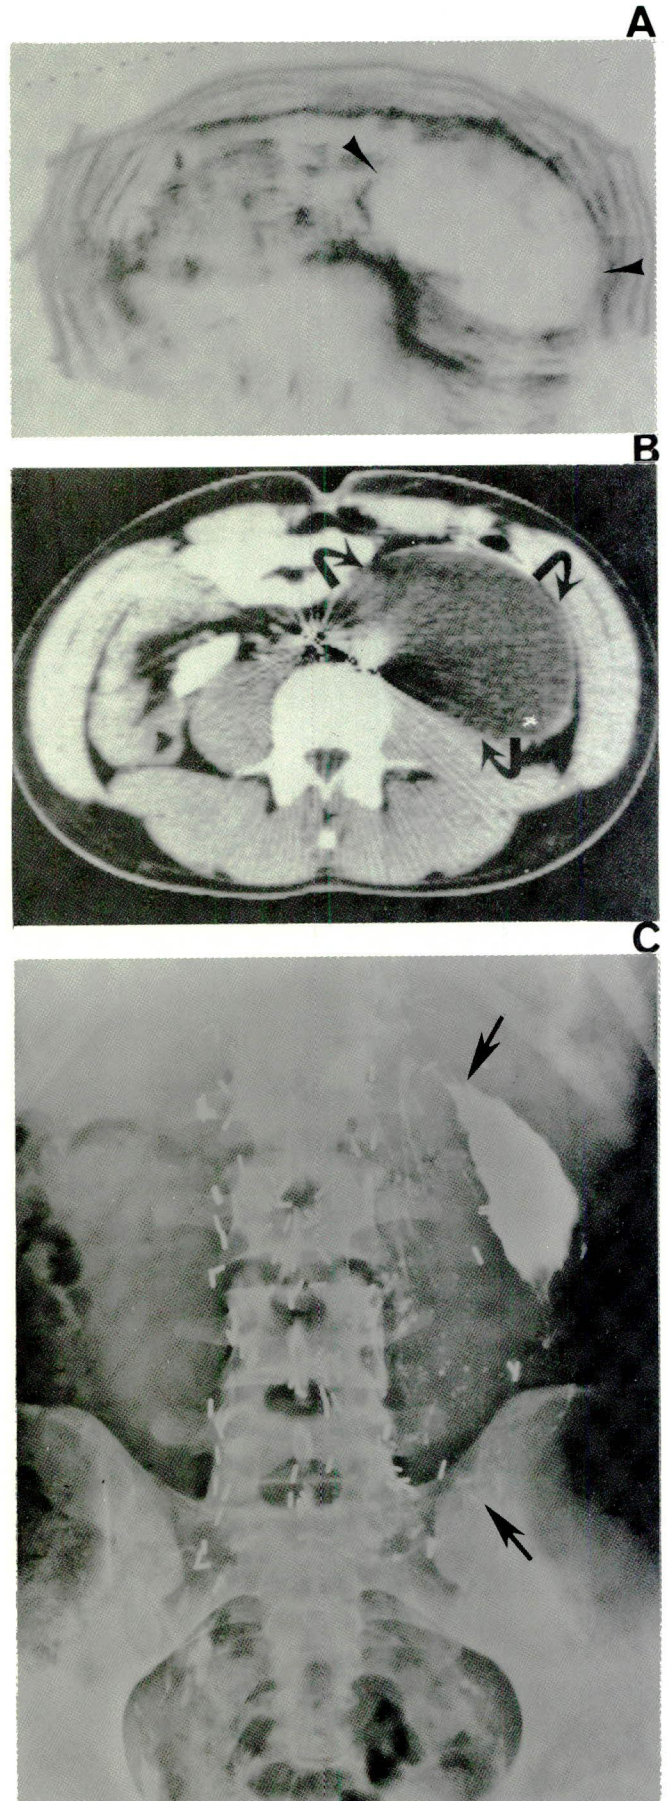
Postoperative lymphocele. 20-year-old male with history of the right testicular mixed germ cell tumor and retroperitoneal lymph node dissection three months previously. A. Transverse sonogram showing large fluid collection in the left side of abdomen (arrowheads). One thousand ml of clear yellowish fluid containing lymphocytes aspirated. B. CT scan 3 days later showed reaccumulation of the fluid (curved arrows). Urogram (not shown) revealed displacement and obstruction of the left ureter. C. Abdominal film following drainage of 1200ml of fluid and injection of pantopaque and ethanol. Notice the contrast material outlining the large cavity (arrows).
